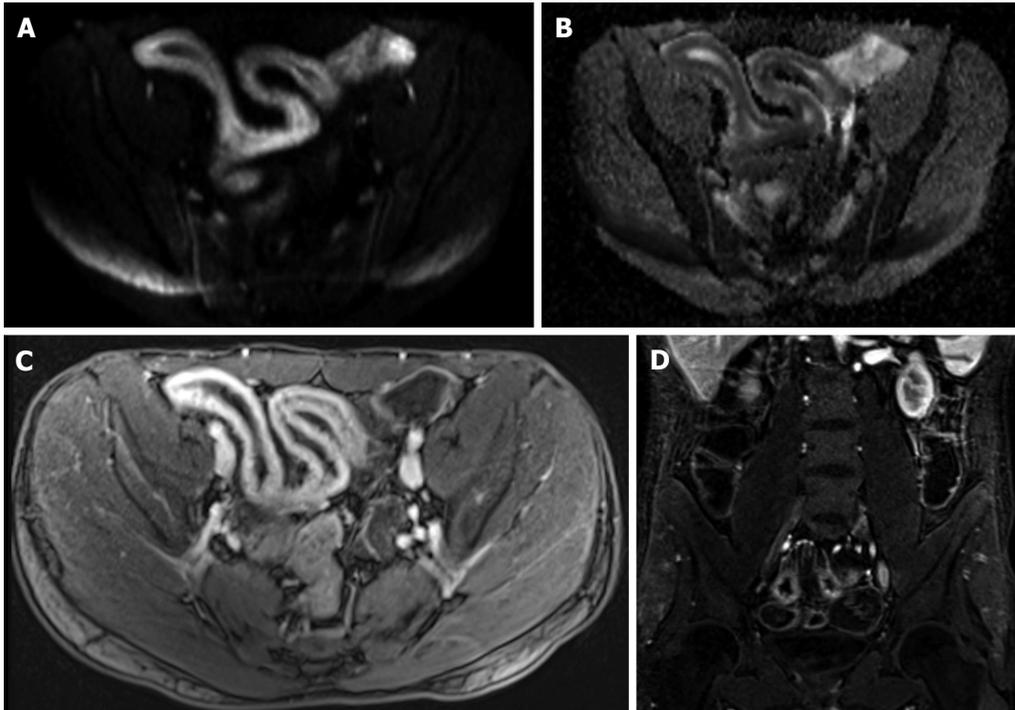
Active distal ileal Crohn's disease. Axial diffusion weighted imaging (A) ($b = 150$) and (B) apparent diffusion coefficient map as well as (C) axial and (D) coronal fat-suppressed post-gadolinium 3D-GRE T1-weighted images. There is a long segment of distal ileal diffuse thickening associated with diffusion restriction (A and B) as well as significant contrast enhancement (C) and vasa recta engorgement (comb sign) (D) in keeping with active Crohn's disease. GRE: Gradient recalled echo.
